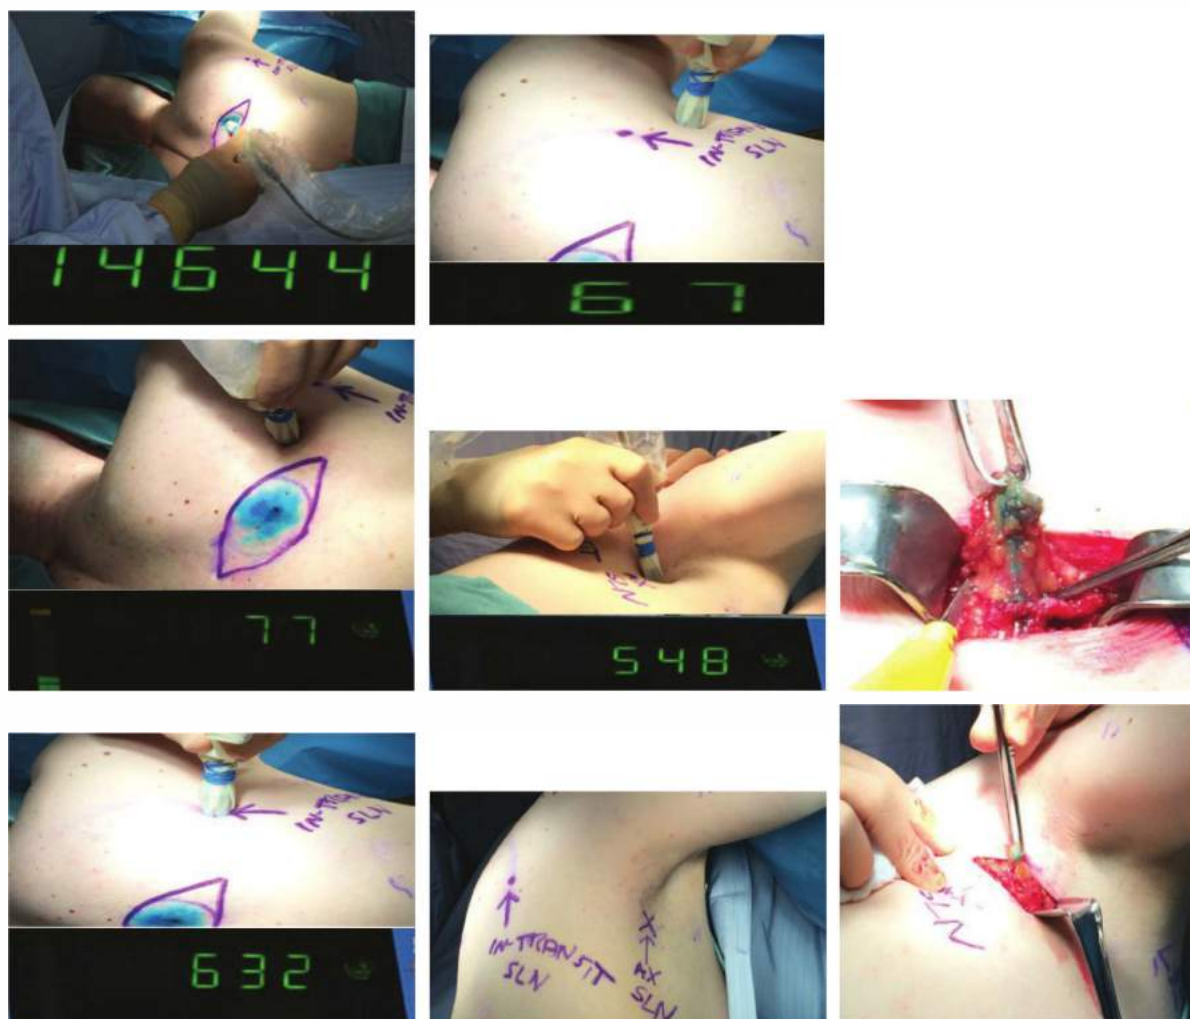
• Thoughtful positioning in the OR. The left lateral position is correctly chosen in this patient with a primary melanoma on the right midback with a lymphoscintigraphy showing drainage to the right axilla and a probable in-transit node over the scapula. This position facilitates not only performing the SLN biopsies and the wide excision without a position change but also scanning for the SLN nodes perpendicular to and directed away from the injection site. Under each frame, the numbers represent the counts per second of radioactivity where the gamma probe is placed. Note that the highest count is over the injection site, then counts decrease moving away from the injection until they increase to identify the in-transit node, then decrease again as the in-transit node is passed, then increase again in the axilla. The last frame in the second column shows the SLN sites marked and in the last column on the right the two frames show the in-transit SLN and the axillary SLN.
